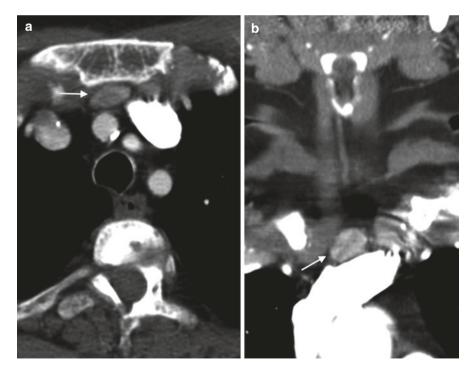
4D-CT: Axial (a) and coronal (b) post-contrast imaging showing an enhancing retrosternal ectopic parathyroid adenoma (arrows)
